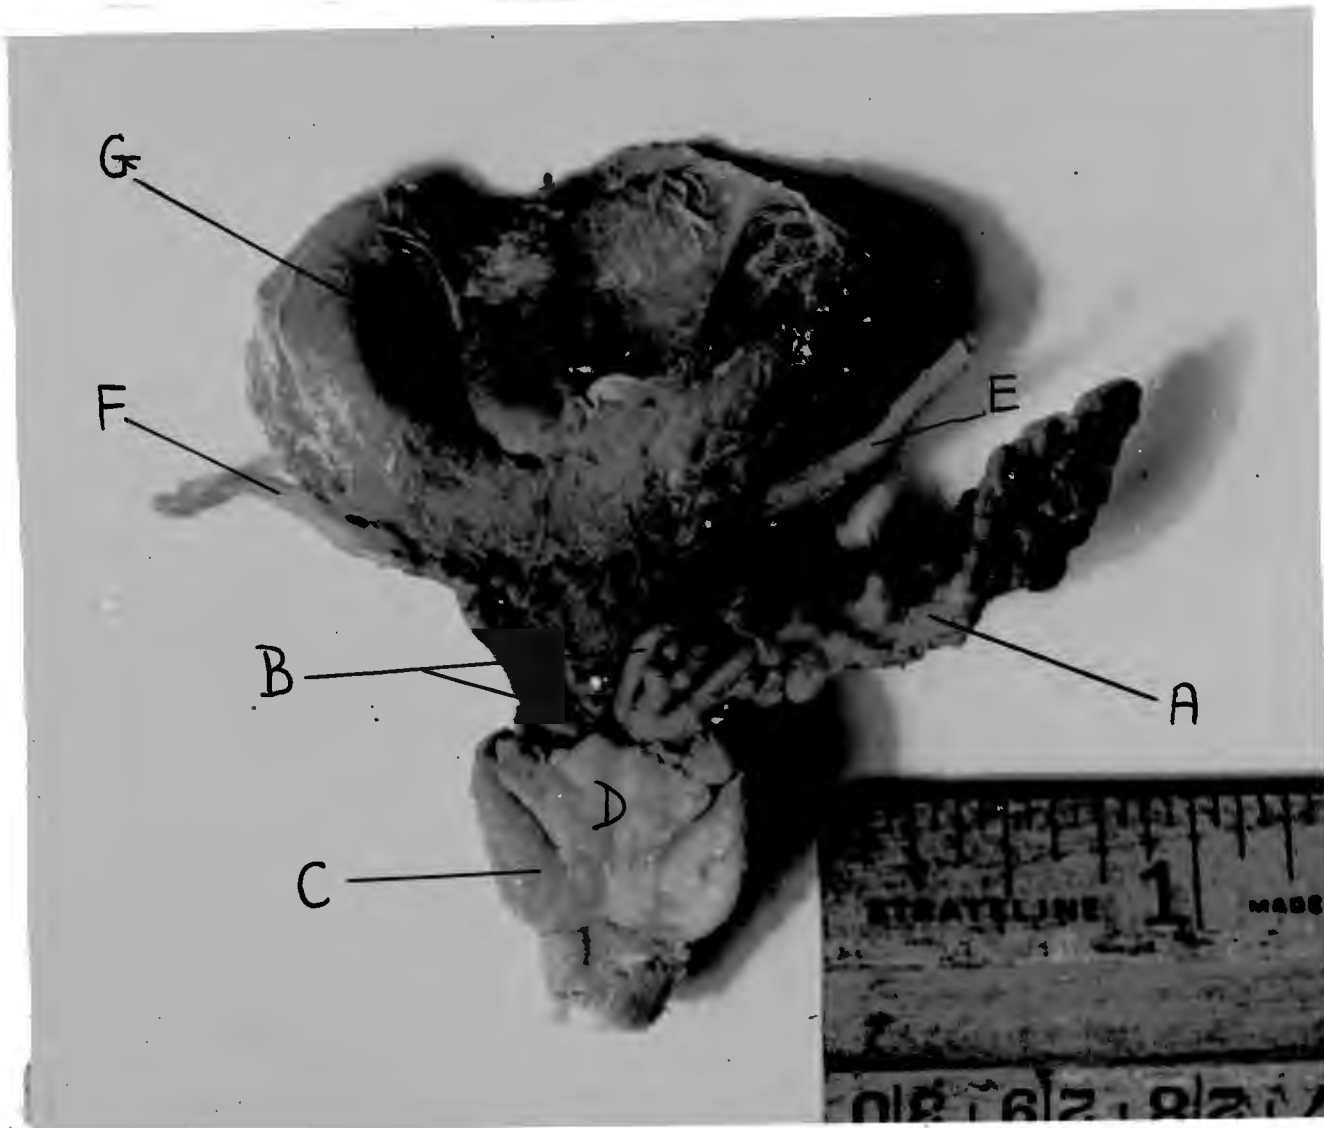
DORSAL ASPECT OF BLADDER AND SEX GLANDS OF AN IMMATURE CHACMA BABOON. TWICE NATURAL SIZE.
